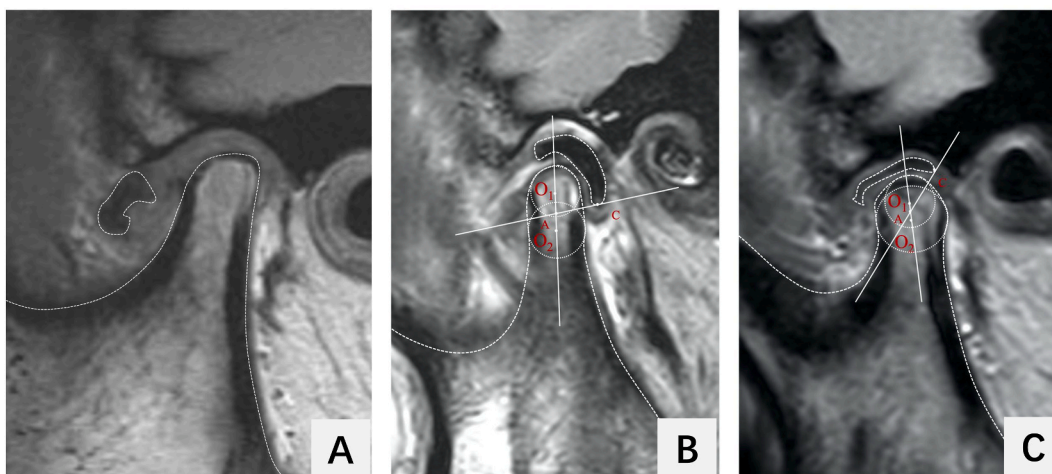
A. Preoperative MRI showed TMJ ADD; B, Immediate postoperative MRI showed the articular disc reset at between the 2 and 3 o'clock direction and dilation of joint cavity; C, 18 months postoperative MRI showed the articular disc located between the 12 and 1 o'clock direction.
